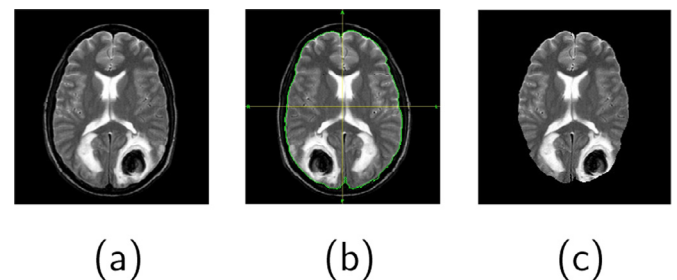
Example of pre-processing. (a) Original brain MRI. (b) Brain boundary detection using Brainsuit. (c) Skull stripped MRI.
